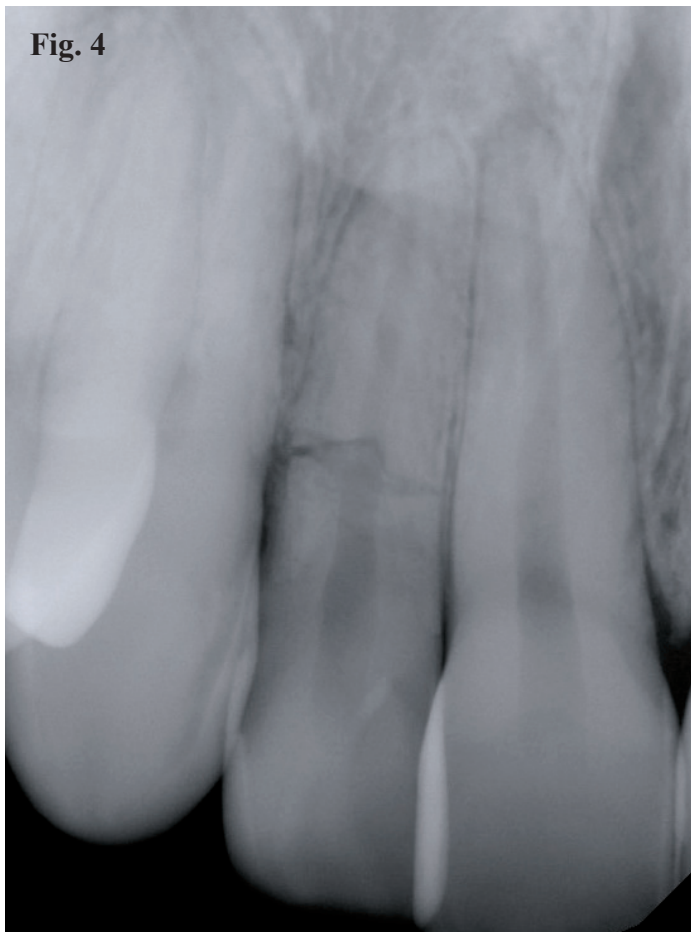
A periapical radiograph reveals a horizontal fracture on the upper right lateral incisor at the level of the crestal bone. Figure 5. A CBCT scan of the fractured tooth reveals good buccal and lingual plates, which would allow a plan for immediate implant placement.
